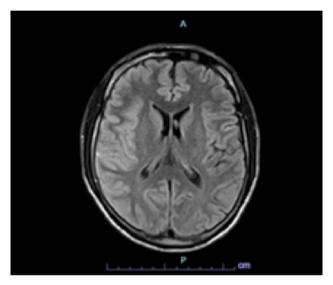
Brain MRI with findings suggestive of right frontal-parietal cortical edema.
